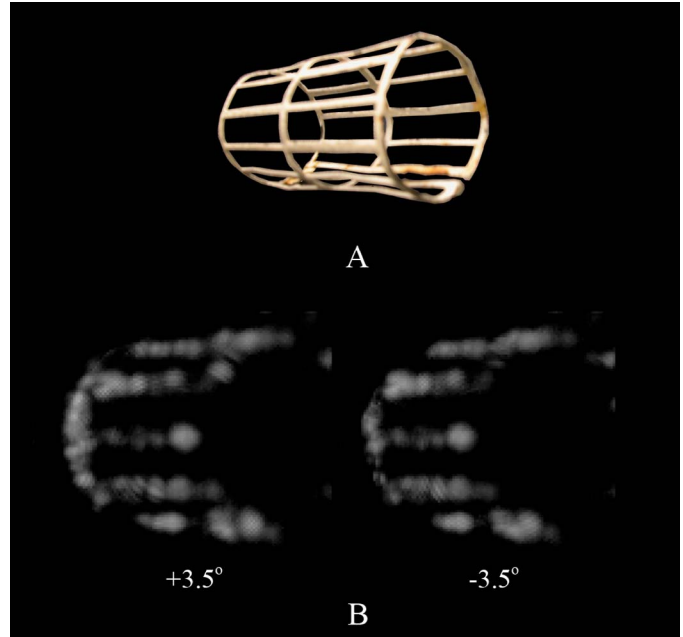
3-D stereoscopic imaging with RT3D ultrasound. The cylindrical metal cage (A) is 4.4 cm in diameter and 8.9 cm in length. The 3-D image is constructed by fusing the volume-rendered left-eye (+3.5°) and right-eye (-3.5°) views (B).
